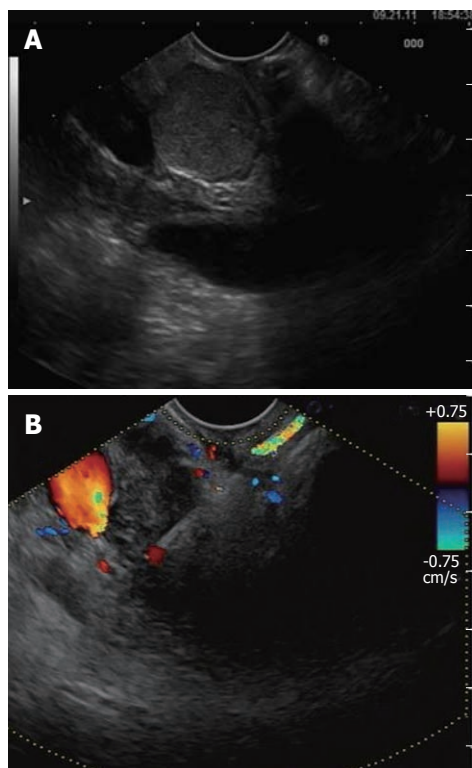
Endoscopic ultrasound evaluation of bile duct mass not seen on transabdominal imaging. A: Endoscopic ultrasound demonstrating the presence of bile duct mass; B: Endoscopic ultrasound-guided fine needle aspiration was diagnostic of cholangiocarcinoma
